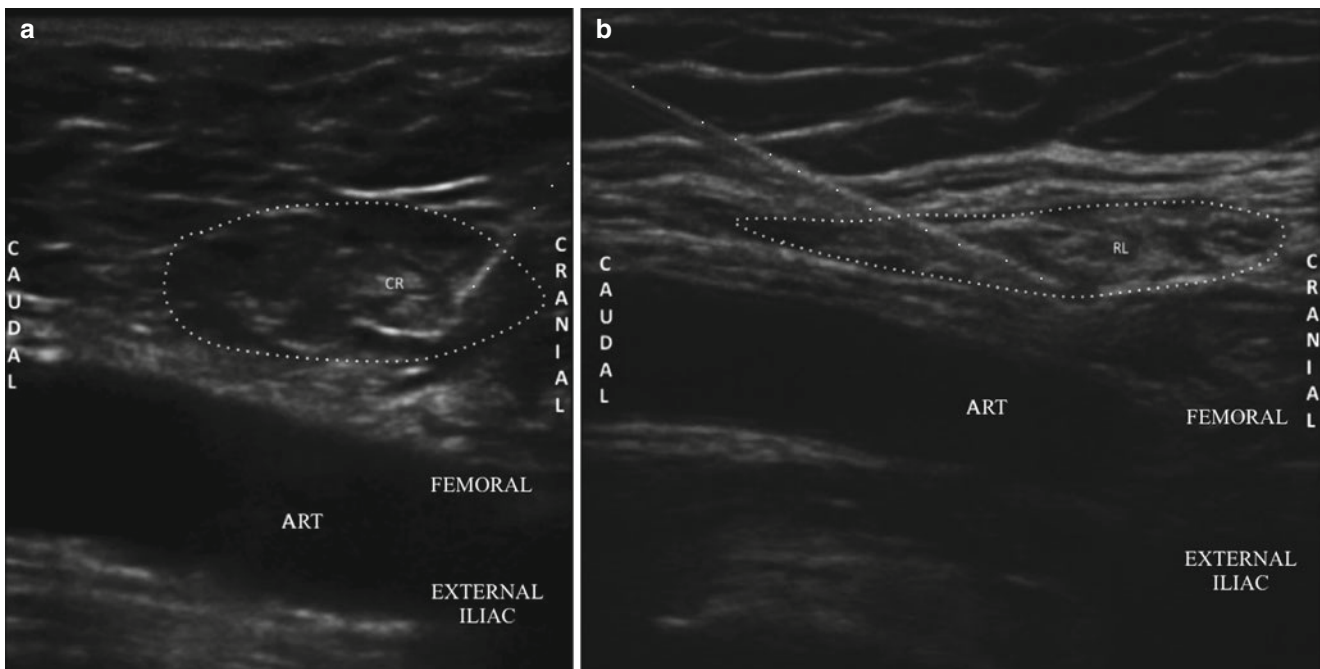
Cross-sectional ultrasound image of the internal inguinal ring filled with local anesthetic and needle tip near the cremaster or round ligament. *Dotted line* represents the internal inguinal ring; (a)
